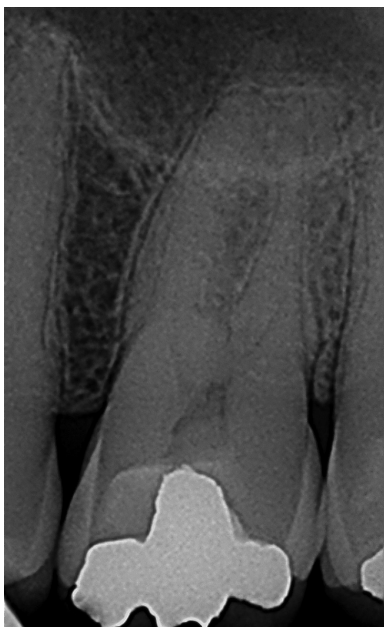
Preoperative radiograph of a maxillary right second premolar
